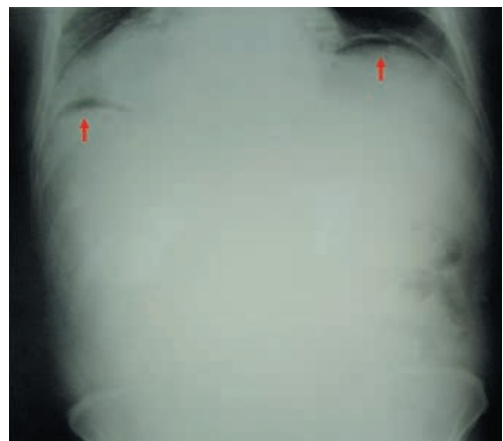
Subdiaphragmatic sickle-like air collection in native plain x-ray in standing position (gastrointestinal perforation).
